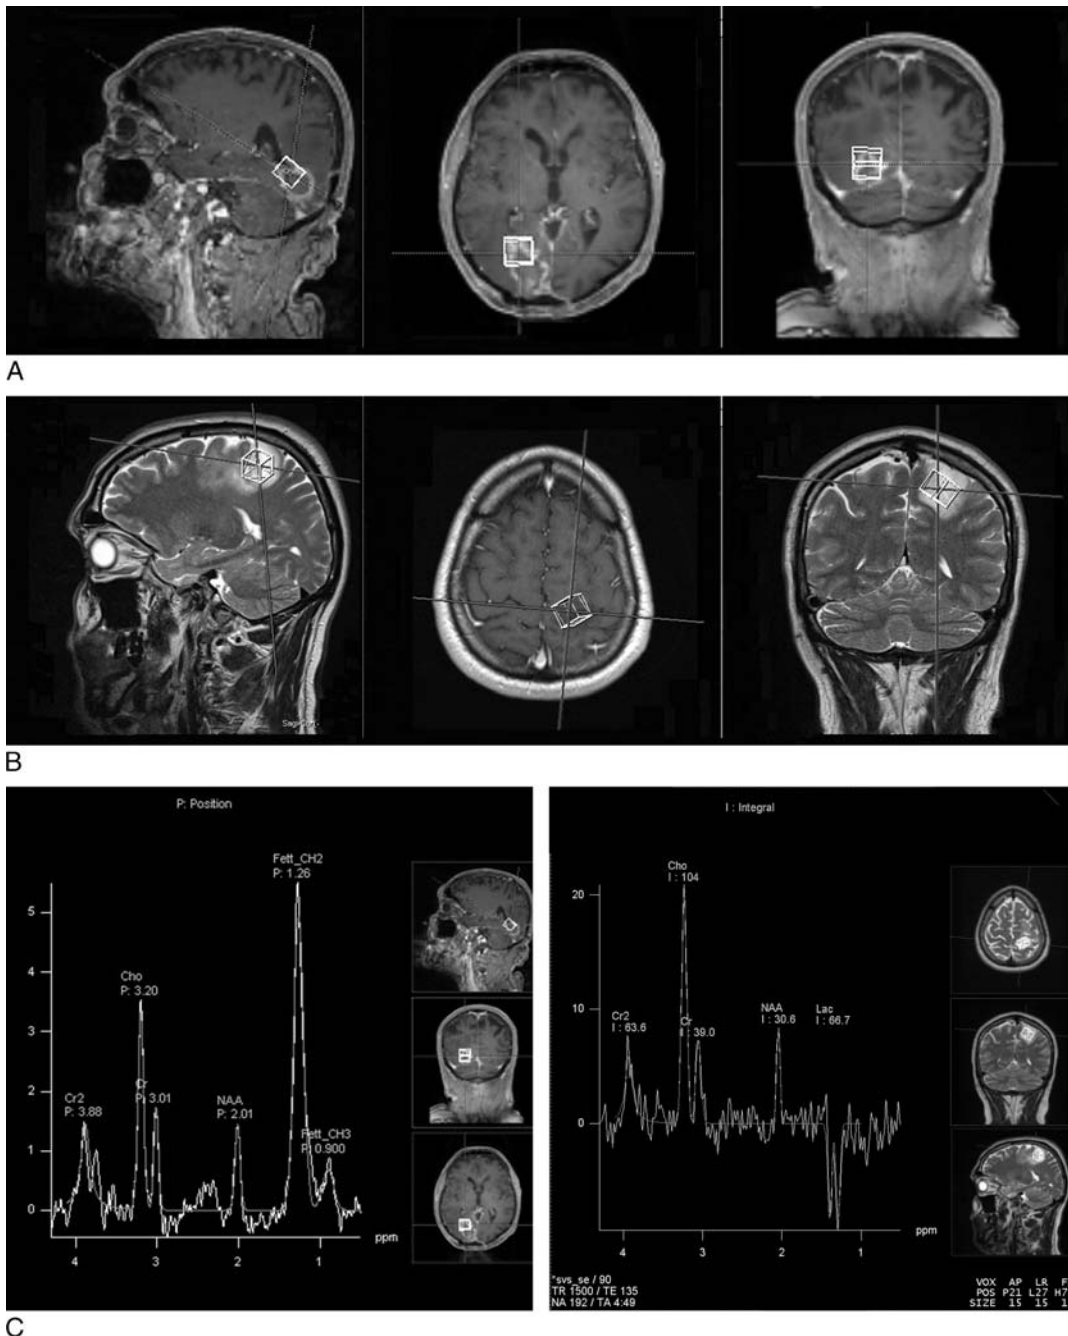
Magnetic resonance images (A) and MRS (C, left) of a glioblastoma. Reduced NAA is found due to neuronal degradation; increased Cho indicates cell proliferation. There are strong lipid peaks, which are typical in high-grade tumors. Magnetic resonance images (B) and MRS (C, right) of a nonenhancing WHO grade III astrocytoma. Choline is increased because of high cell turnover with anaerobic metabolism (lac peak). N-acetyl-aspartate is reduced because of destruction of normal brain tissue.
